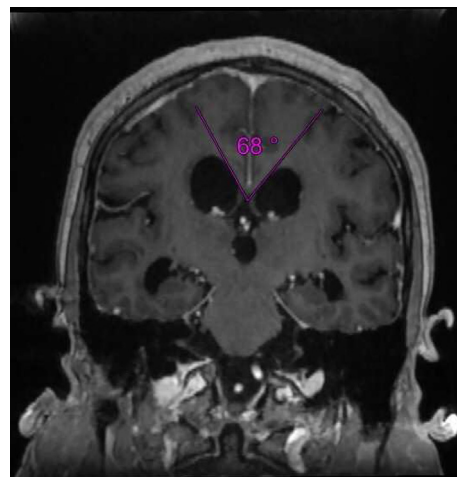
Coronal brain MRI with contrast showing ventricular system dilatation with mild transependymal edema consistent with hydrocephalus. Callosal angle of 68°.
